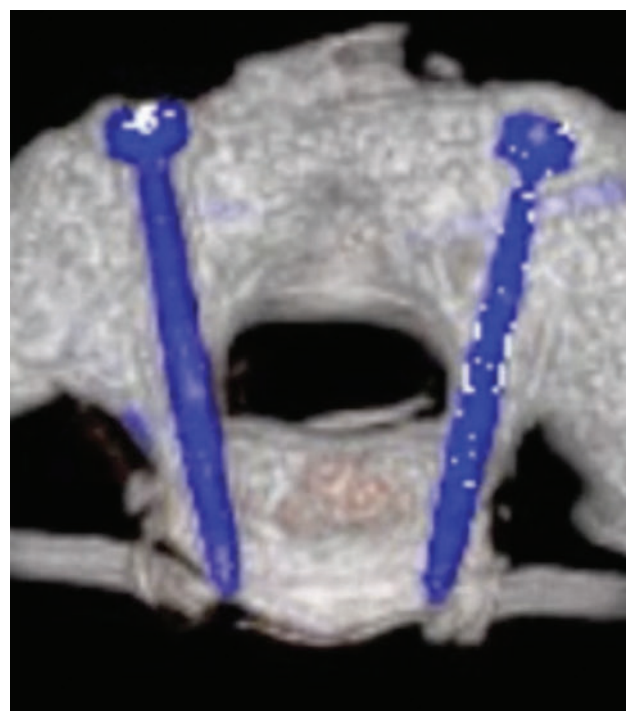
Postoperative sagittal CT scan of T12, optimized to detect metallic objects and show them as blue.
